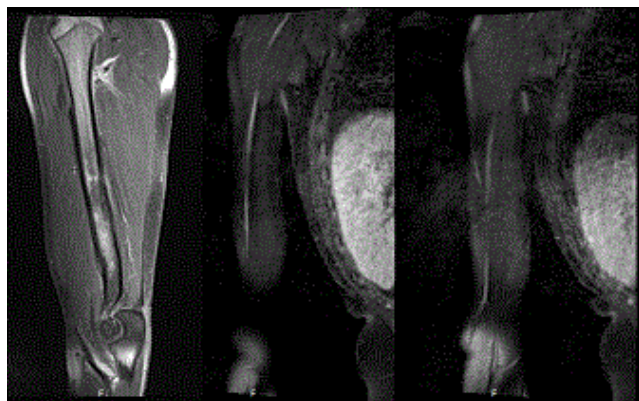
Nuclear Magnetic Resonance Images, performed after four months of injury, during follow-up: Bone hypertrophic changes in the fracture region determine stretch in the radial nerve pathway in the middle third of the posterior lateral aspect of the arm, at the crossroads with the humeral shaft, showing thinning and diffuse hyperintense, asymmetric relative to the proximal and distal nerve course. In study after contrast is observed discrete hyper signal of this segment for possible post-traumatic inflammation. The proximal and distal nerve segment has characteristics maintained.
